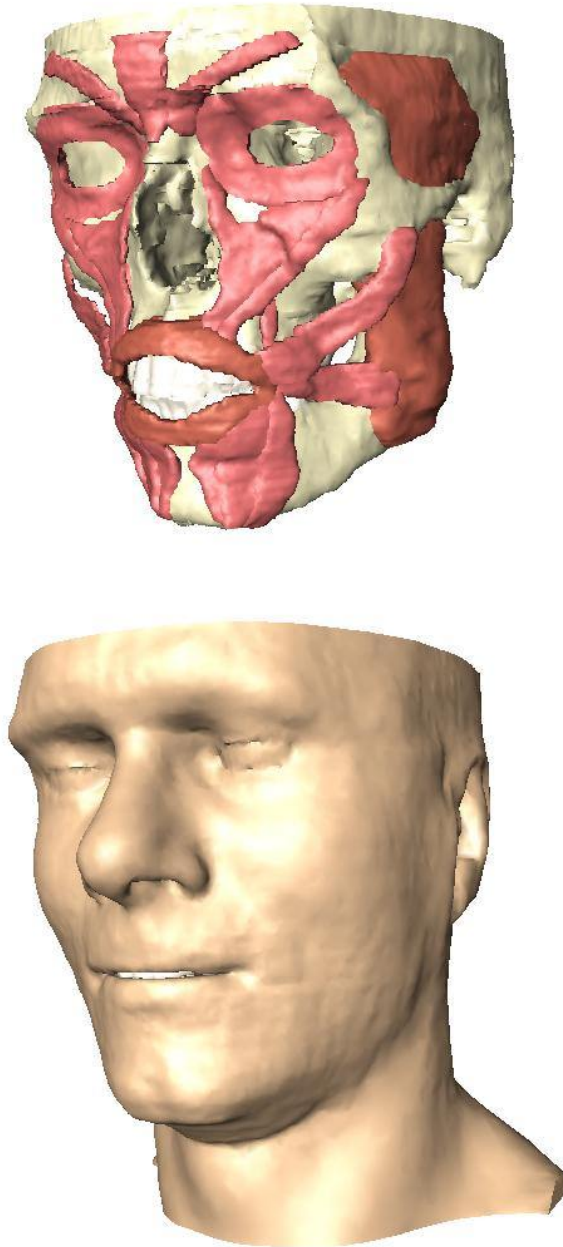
Detailed geometrical model of human head generated on the basis of MRI volunteer data (from [118]). Top: inner view, surface model of mimic musculature. Bottom: outer view, skin surface.
